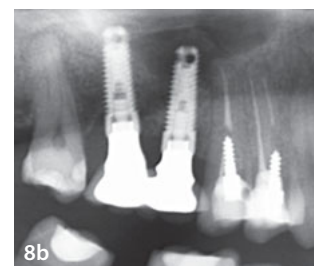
Panoramic radiograph 8 months post-implantation with crown rehabilitation. Note the bone in the sinus around the DIVA implant at the maxillary right first molar.
